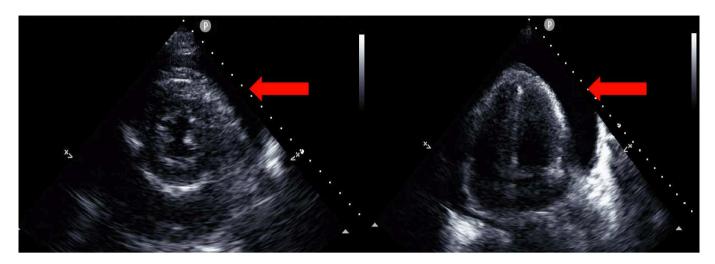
A,B, Echocardiography on arrival to the hospital. A, Parasternal left border left ventricular short–axis image showing pericardial effusion (red arrow). B, The apical tetralogy of the pericardium also shows pericardial effusion (red arrow).
